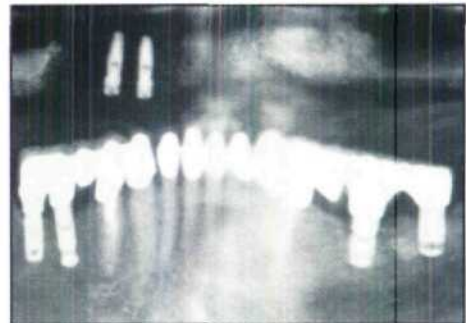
Postoperative radiograph of the definitive implant-supported fixed partial denture (mandibular right), which was in function for 5 years.
